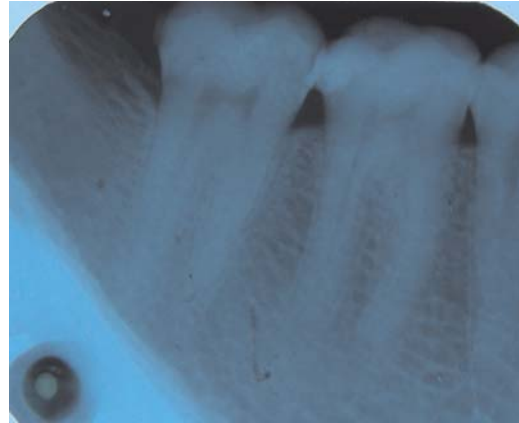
Radiograph showing defects in distal region of 46
